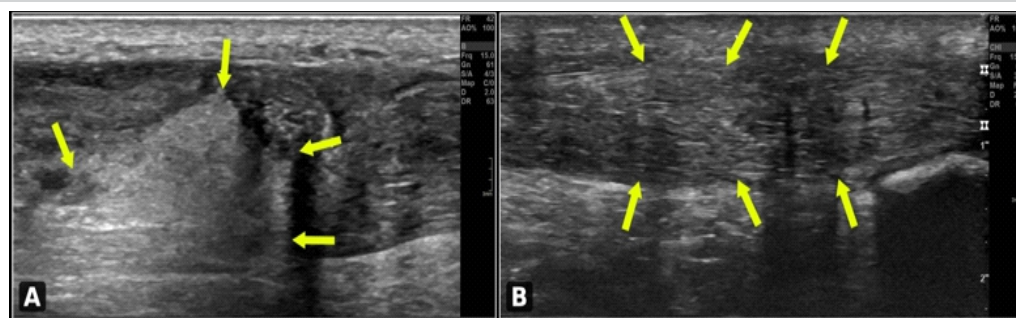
Ultrasound images of the right Achilles tendon: (a) pre-operative image demonstrating complete tendon rupture with loss of continuity and hypoechoic gap (yellow arrows indicate the rupture margins); (b) 3-year follow-up demonstrating restored tendon continuity with no evidence of re-rupture (yellow arrows delineate the intact repaired tendon).
